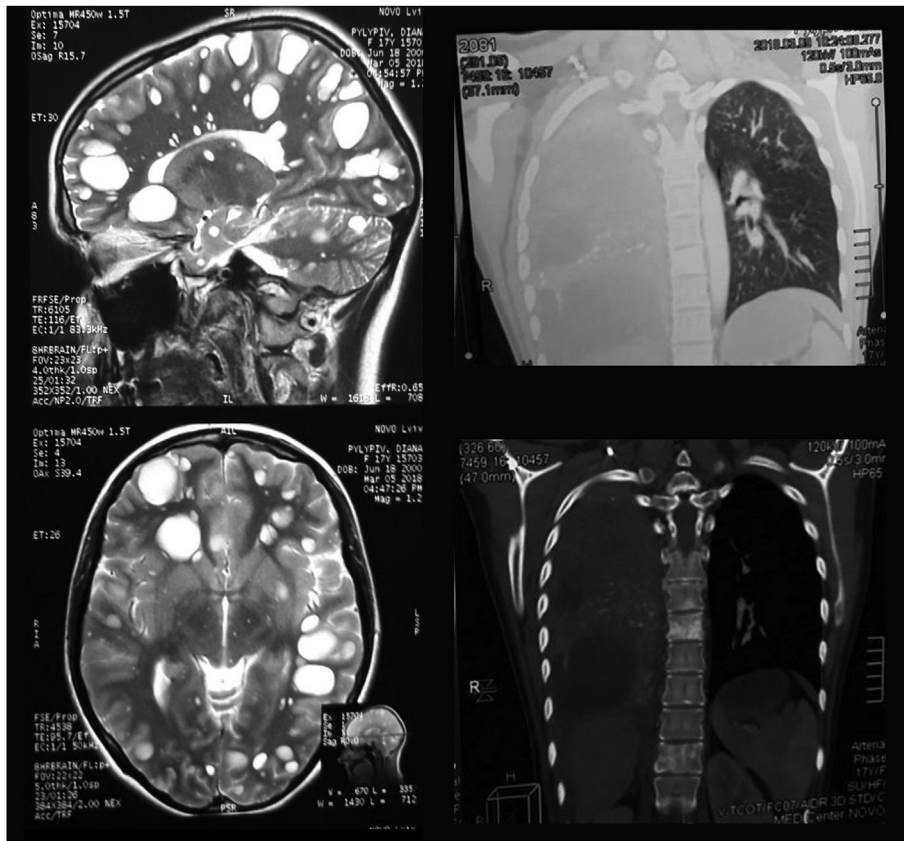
Brain MRI: diffuse cyst-like formations in the parenchyma of the brain, cerebellum. The ventricular system is not dilated and the lateral ventricle bodies are symmetrical. Computed tomography results: in the right lung projection, a massive pathological heterogeneous process is visualized. It causes obstruction, right main bronchus rupture and right lung atelectasis, and compression of the right artery and its branches. A large amount of fluid in the right pleural cavity. Osteosclerotic destruction of Th1–Th4, Th8, Th12, L2 bodies, and wedge-shaped deformation of the Th12 body.
